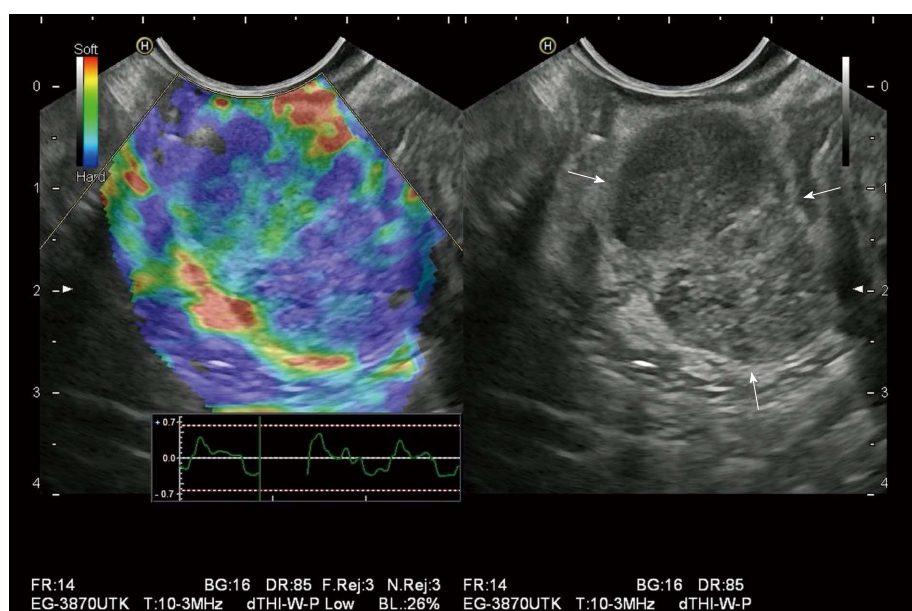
Gastrointestinal stromal tumor is revealed heterogeneous hard (blue) pattern on endoscopic ultrasound elastography.
